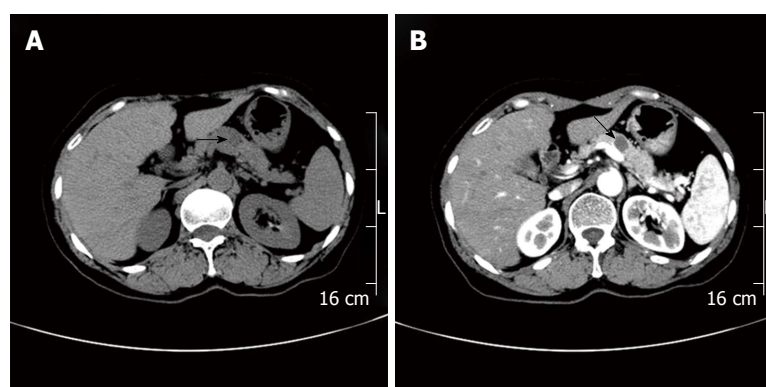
Computed tomography findings. A: An unenhanced CT scan showed a 1.6 cm × 1.1 cm well-defined hypodense mass (arrow) in the pancreatic body; B: On the contrast-enhanced CT, the mass (arrow) was not enhanced. CT: Computed tomography.
